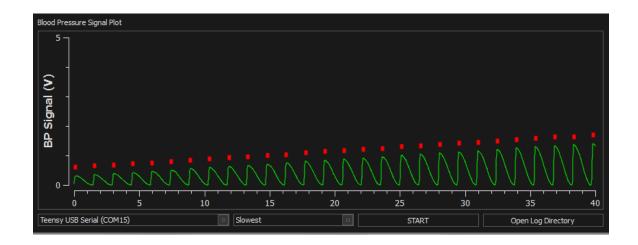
Gradual increase in gain to amplify a low amplitude blood pressure signal. The red markers indicate when the triggering signal was sent to the MRI scanner.
